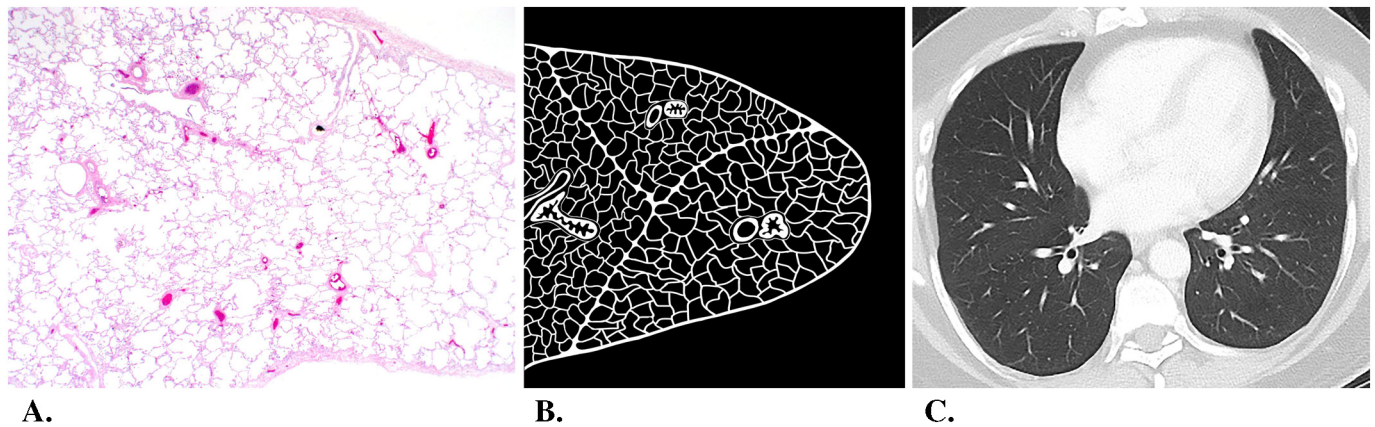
A and B. Normal anatomy of the secondary pulmonary lobule. Each lobule contains a central bronchovascular bundle. At the periphery of the lobules are subtle interlobular septae. C. Normal CT image of the lung parenchyma with subtle interlobular septae. Reprinted from [Smith M, Update on Pulmonary Fibrosis: Not All Fibrosis Is Created Equally. *Arch Pathol Lab Med.* 2016; 140 (3):221–229] with permission from Archives of Pathology & Laboratory Medicine. Copyright 2016 College of American Pathologists.
